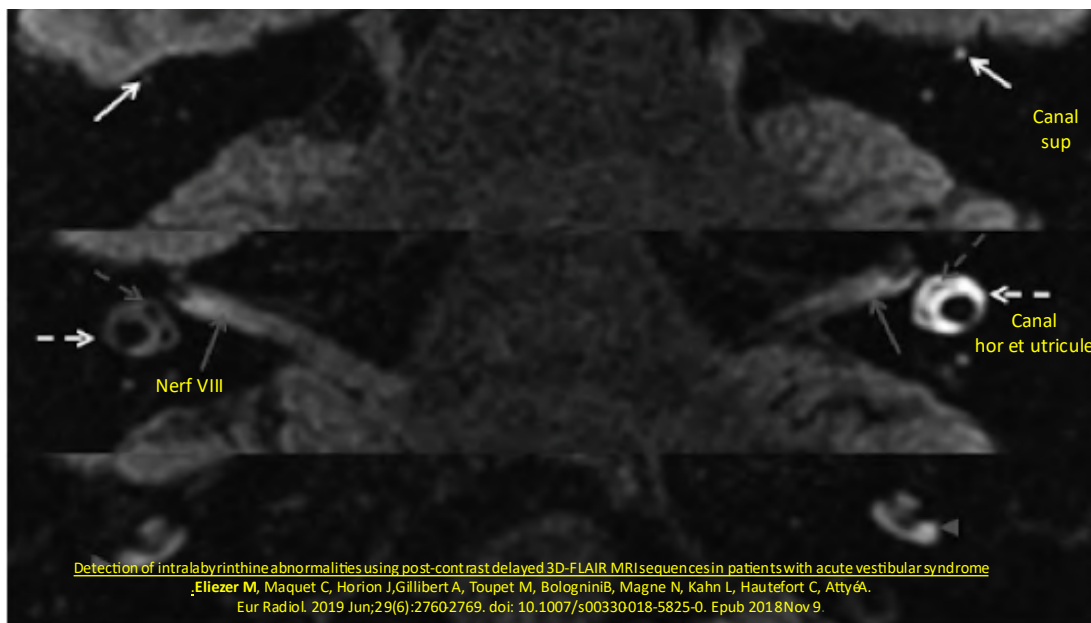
MRI imaging of a "vestibular neuritis" patient
